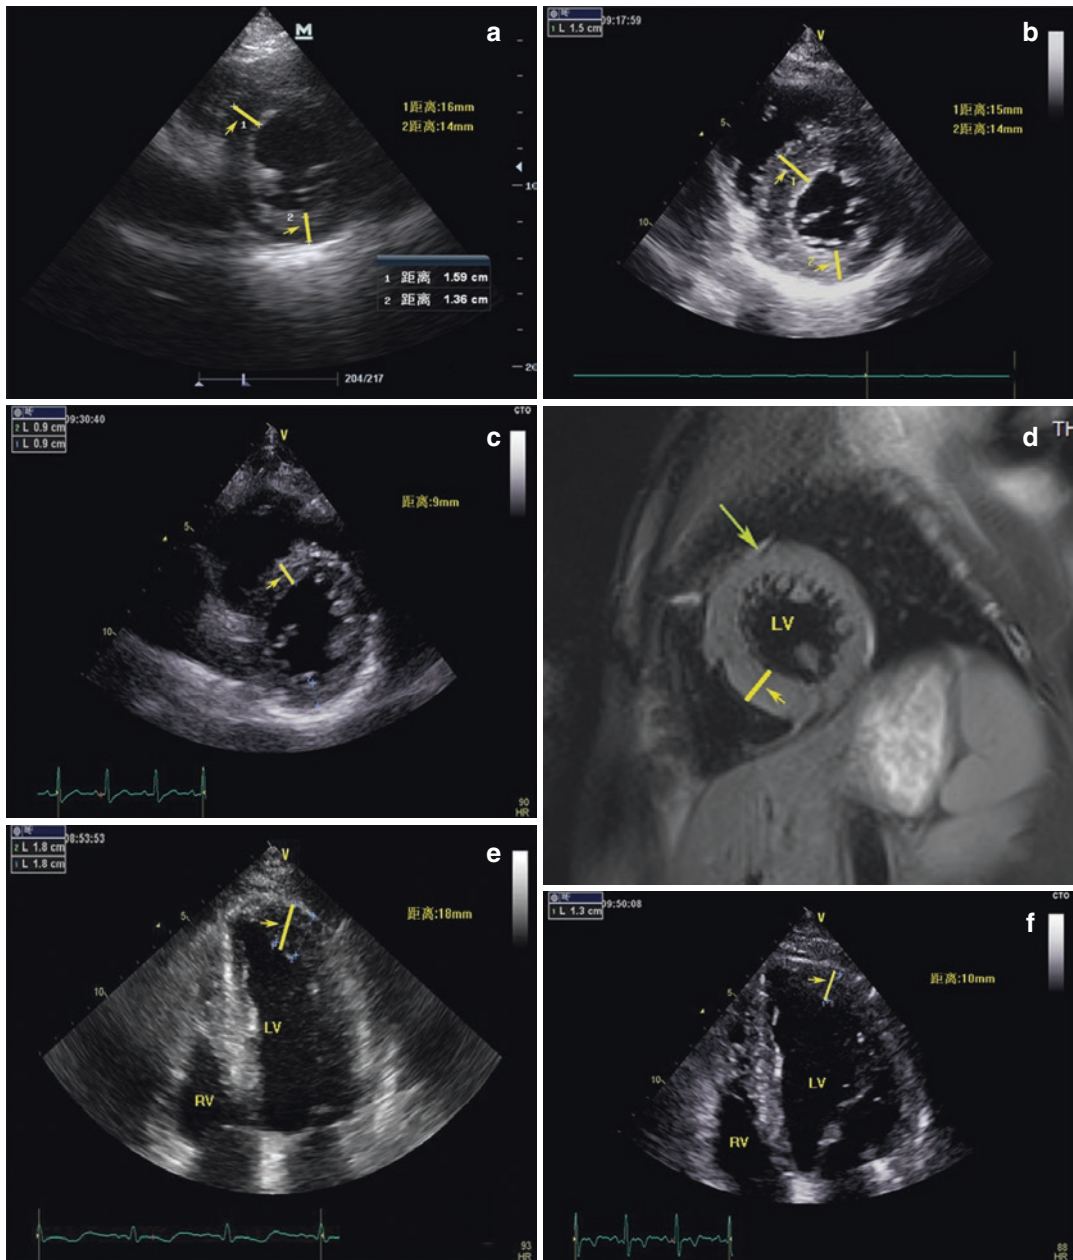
Echocardiographic (a–c) and CMRI (d) short axis views in a patient with FM, and apical four chamber views in another patient with FM (e and f). (a) Thickened interventricular septum (16 mm) and posterior wall (14 mm) on admission; (b) Septal thickness was 15 mm and posterior wall thickness was 14 mm before discharge;
